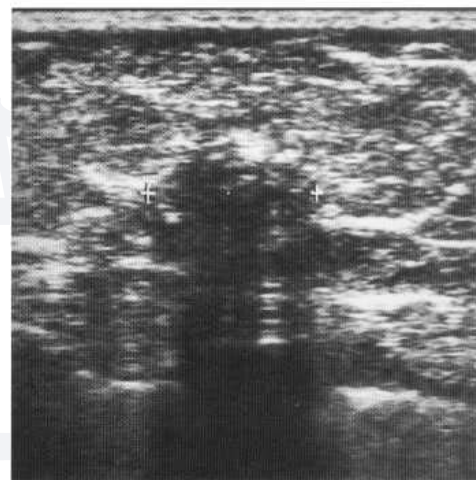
Ultrasound showing an echo-poor mass with irregular margins and posterior acoustic shadowing due to a carcinoma.
